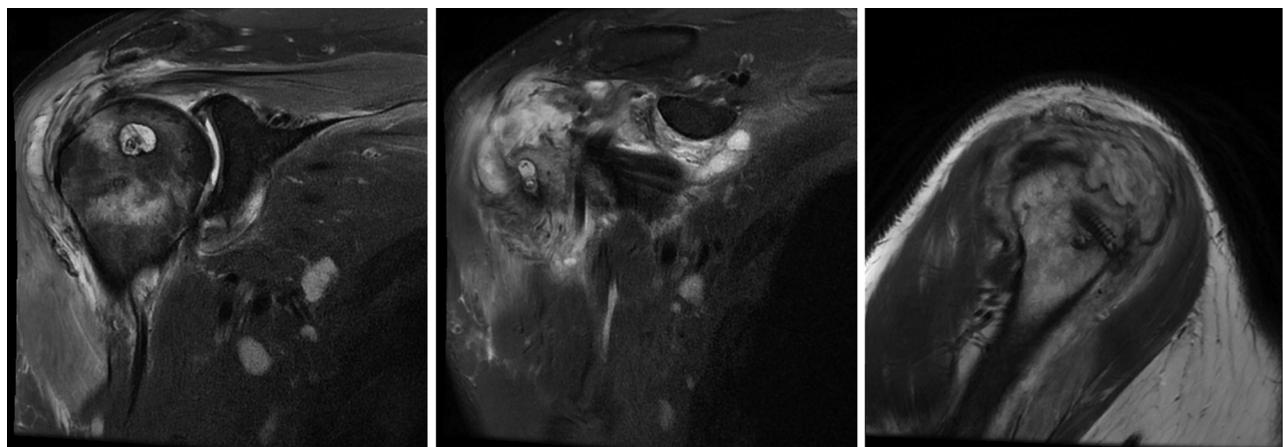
Postoperative MRI images on POD 47 showing a large loculated fluid collection in the subacromial space with disruption of the rotator cuff repair and lucency around the previously placed anchors. *MRI*, magnetic resonance imaging; *POD*, postoperative day.
